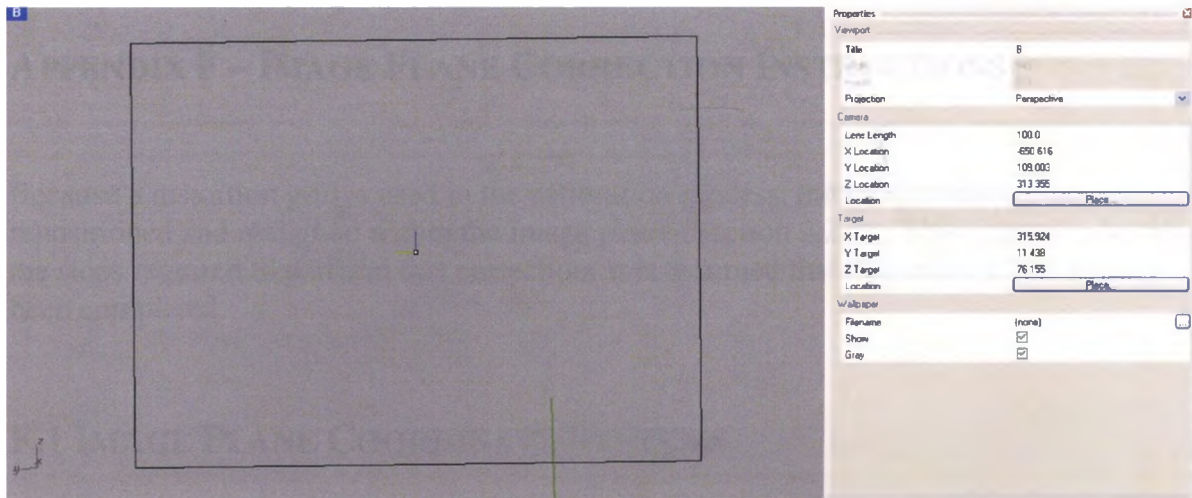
X-ray source modeled as a perspective camera
